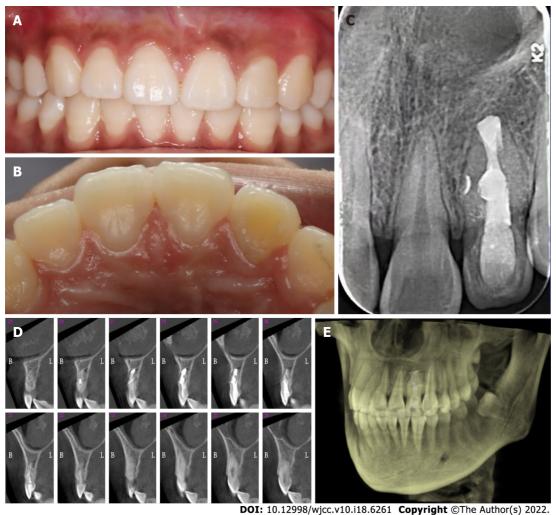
Follow-up photographs and radiograph. A: Three-year recall labial view; B: Three-year recall palatal view; C: Three-year recall radiograph. The obturated lateral canal was visualized; D: Sagittal sections showing bony healing; E: Three-dimensional reconstruction indicating continuous bony plates.
